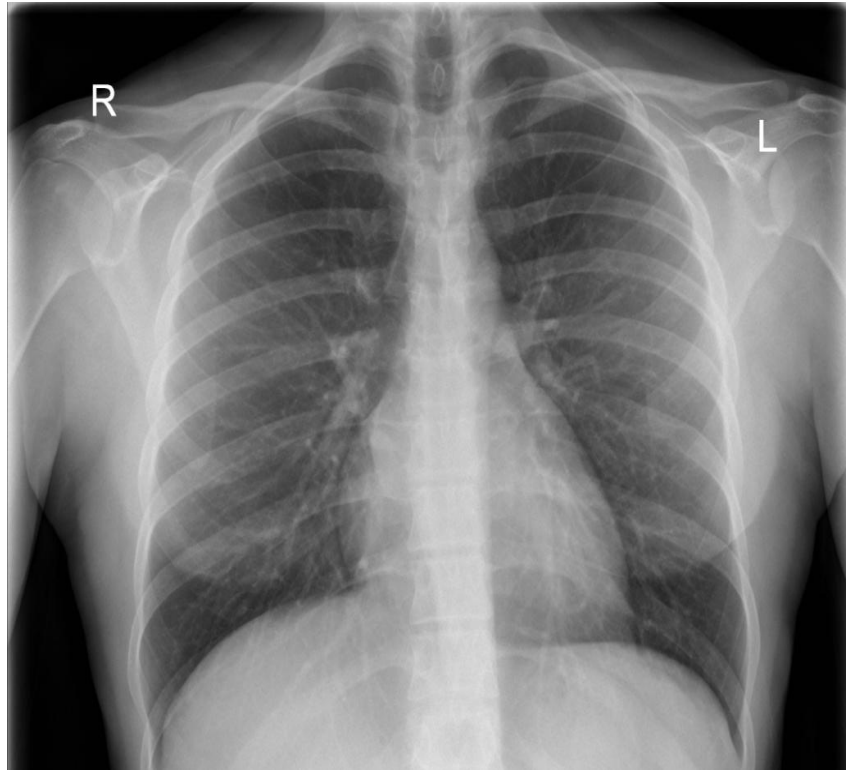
Normal plain chest Radiograph
